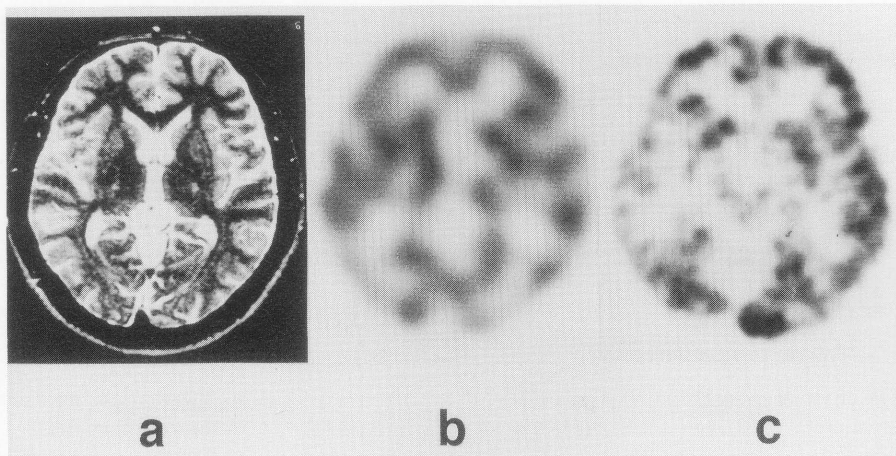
A 16-year-old man with complex partial seizure. (a) The high intensity lesion was located at left mesial temporal lobe (arrow) on T2 weighted MRI (TR 2300/TE 80). (b) Decreased accumulation of Tc-99m HMPAO was observed at left temporal lobe. (c) Decreased glucose metabolism was demonstrated at left temporal lobe, as similar to the hypoperfused area with SPECT.
